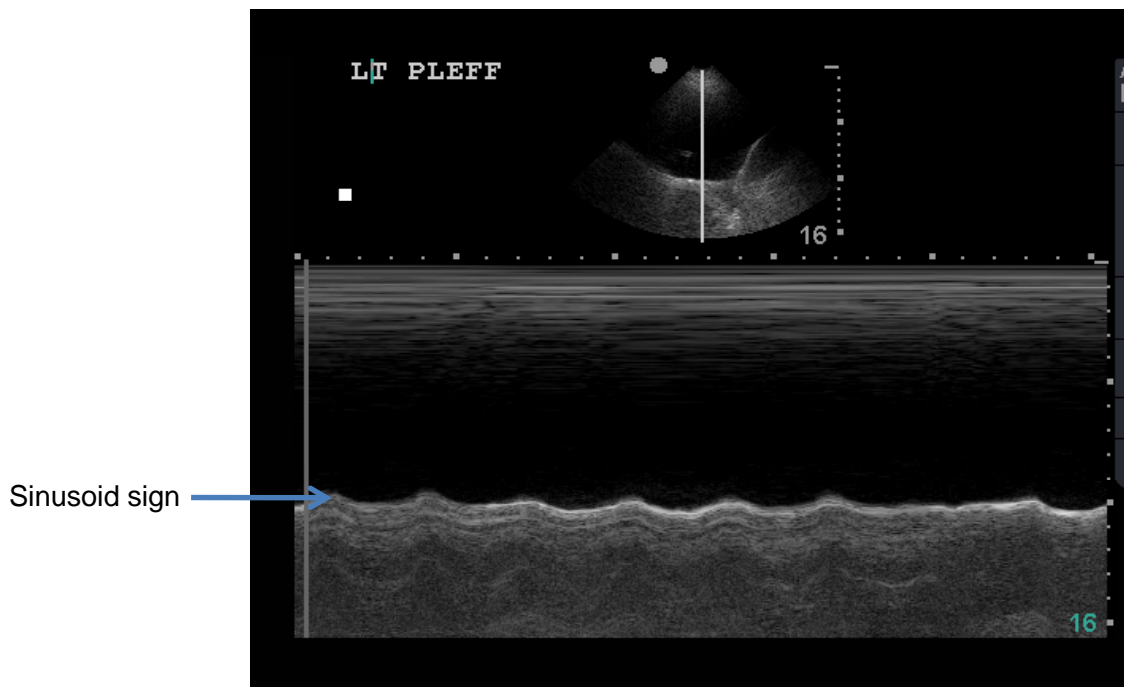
Undulating movements of the lung and visceral pleura in a pleural effusion generate the sinusoid sign in M-mode ultrasound.
